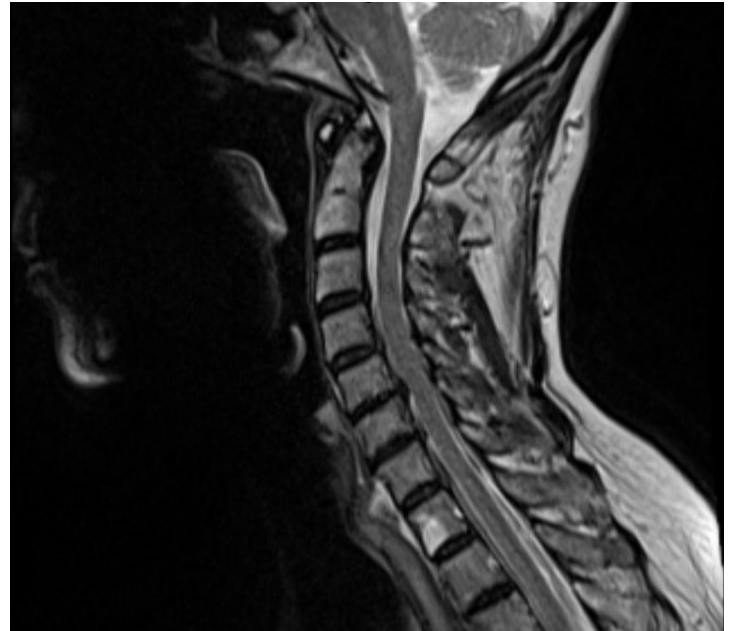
Sagittal T2 weighted MRI image of the cervical spine: Cervical MRI revealed multilevel degenerative disc disease with areas of disc extrusion and mild central canal stenosis without cord compression. There were multiple levels of neural foraminal stenosis primarily affecting the lower cervical region. In the upper cervical region, at C2-C3, there was mild left uncovertebral joint arthropathy and mild left neural foraminal narrowing.
